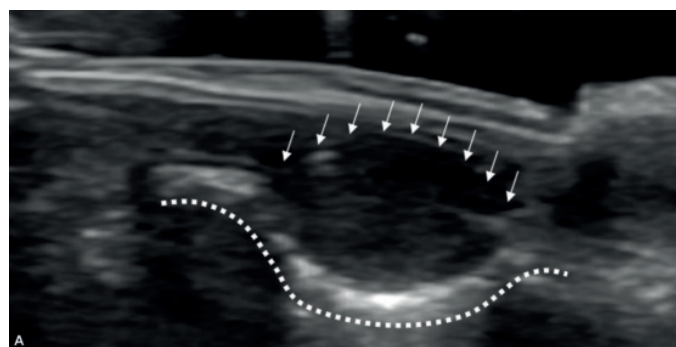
Ultrasound examination performed in the sagittal plane, B mode, with 18 MHz probe, showing a nodular, hypoechoic image with well-defined borders (arrows) in the medial nail bed, causing bone remodeling in the underlying distal phalanx (dotted line).
